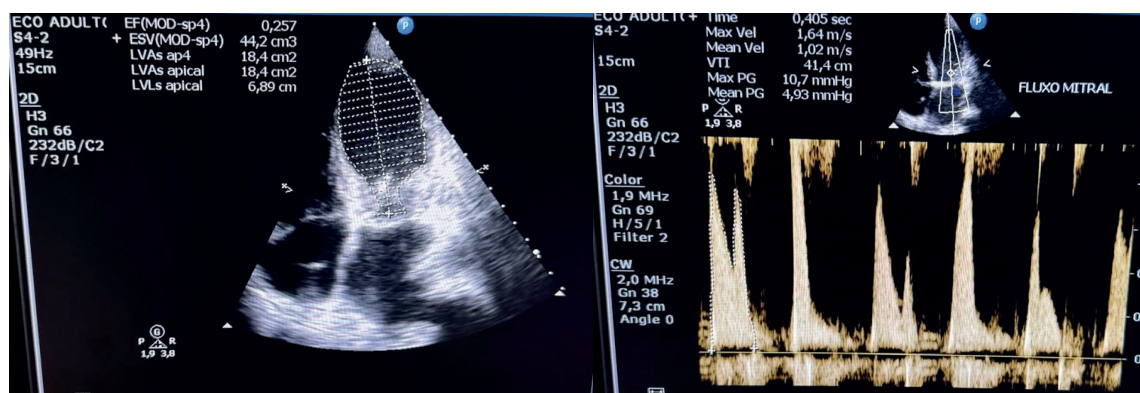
Transthoracic echocardiogram shows akinesia of the mid-apical segments of all walls and preserved contractility only in the basal segments, with significant deterioration of the ejection fraction. Measurement by the Simpson method revealed an ejection fraction of 26%. The adjacent image also displays mitral flow, where the presence of cardiac arrhythmia compromised the assessment of diastolic function.
